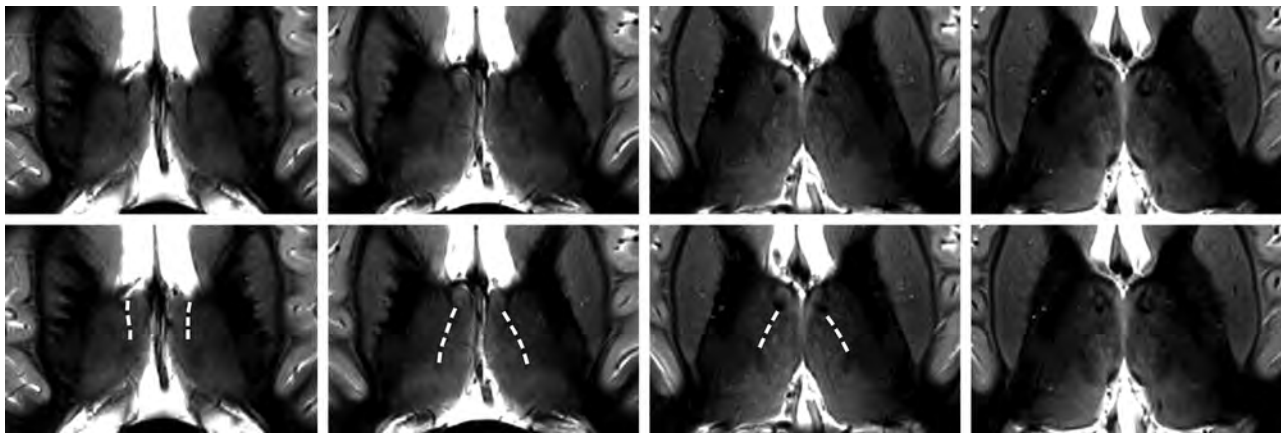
Axial MR images of the thalamus at different positions. Sections are located 16, 13, 10, and 7 mm dorsal to the ACPC plane (from left to right) and acquired with an IR-TSE sequence ($T_1 = 480$ ms and $0.5^2 \times 3$ mm³ resolution). In the bottom row, which is identical to the top row, the La.m is indicated by dashed lines.
